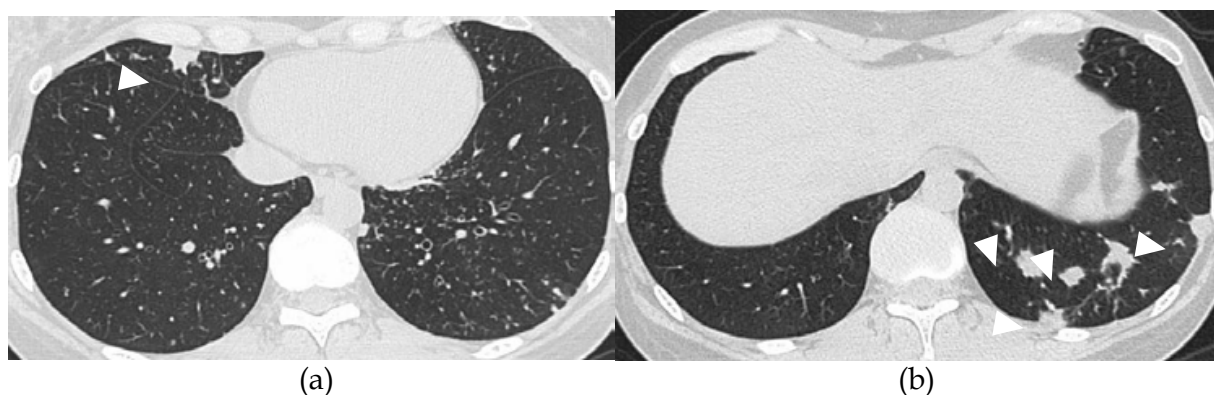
HRCT images of the lungs of a 32-year-old woman with RA (stage 4, class 2) who had been suffering from sinusitis and respiratory symptoms. *M. avium* was detected in the patient's sputum culture despite of antimycobacterial treatment. Multiple nodules (arrowheads) were seen in the right middle and left lower lobes ((a) and (b)). Centrilobular tree-in-bud opacities with slight bronchiectasis were seen in the left lower lobe (a). EIA results were positive for the level of anti-GPL core IgA antibodies (0.88 IU/l).
